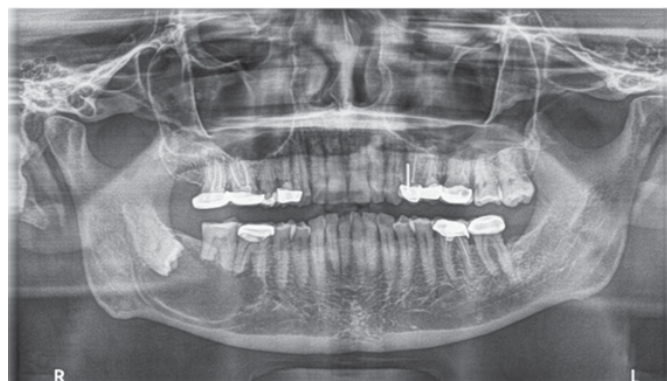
Preoperative orthopantomogram revealing the well circumscribed, unilocular radiolucency.
